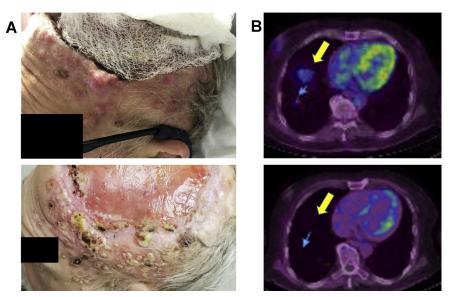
Examples of patients with advanced CSCC who have responded to PD-1 inhibitor treatment. (*A*) Patient who developed extensive dermal metastases that rapidly developed 6 weeks after wide resection of a large, advanced scalp squamous cancer (*arrows*). The patient reduced his immunosuppressive medication for a renal transplant allograft and was given 2 cycles of cemiplimab, with an outstanding response (*lower panel*). (*B*). Example PET-computed tomography imaging from a patient with advanced scalp CSCC who developed pulmonary metastases (*upper panel [arrow]*). Durable CR after 1 year of ongoing cemplimab treatment (*lower panel [arrow]*).
